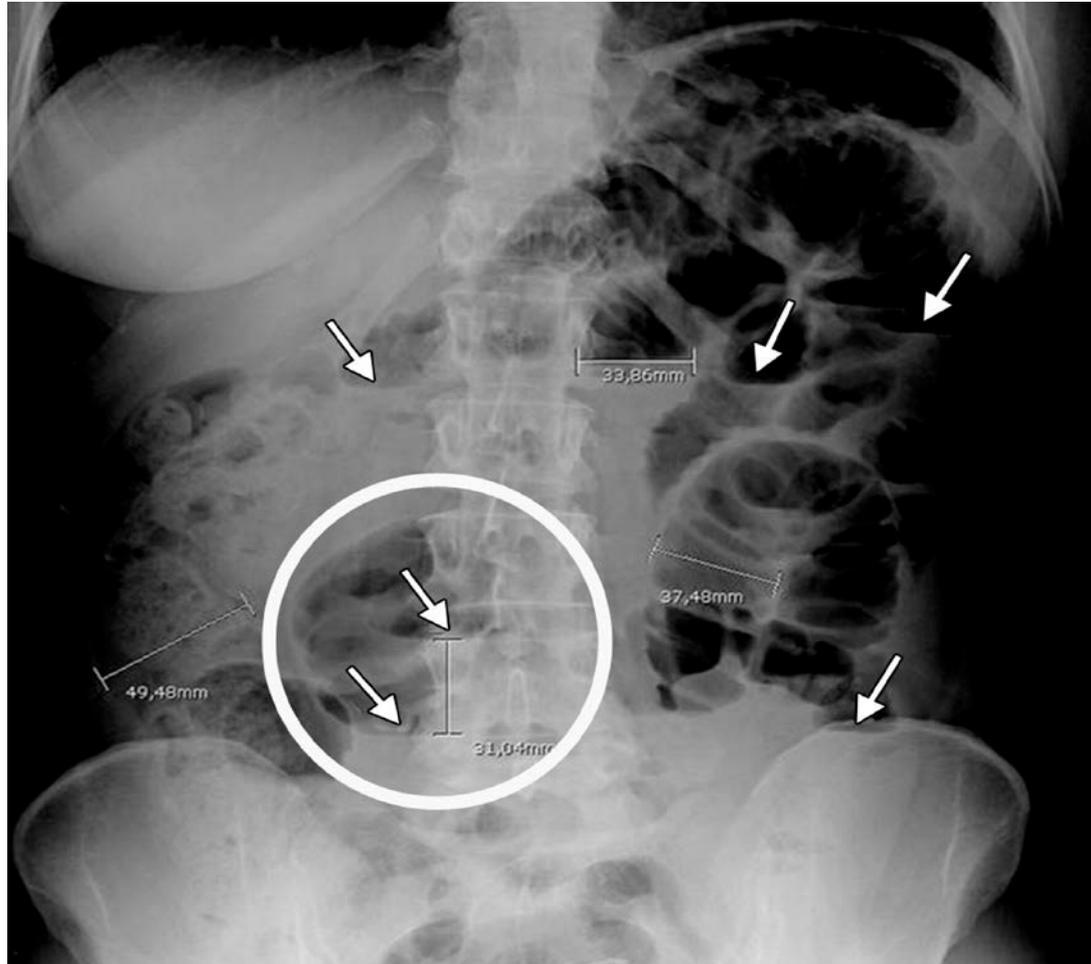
High-grade SBO. Published in: Ana Catarina Silva; Madalena Pimenta; Luis S Guimaraes; *RadioGraphics* 2009, 29, 423-439.
